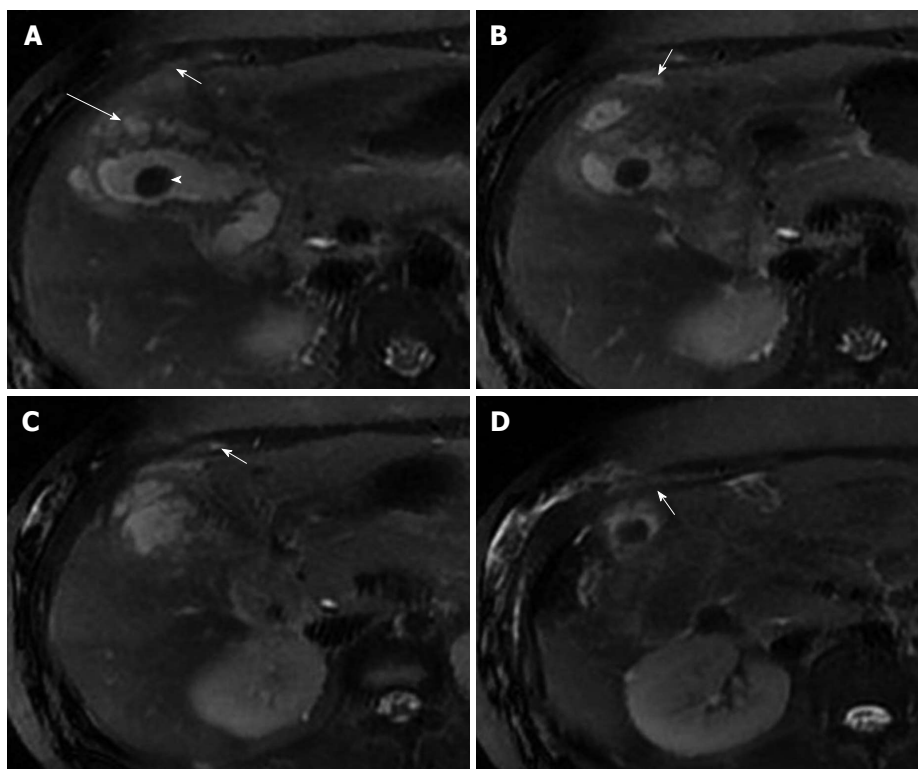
Axial sequential T2W magnetic resonance images (A-D) showing multiple hyper-intense intramural collections in gallbladder (long arrow) with extension of inflammatory process into the pericholecystic region, poor fat planes and involvement of the anterior abdominal wall (multiple short arrows). Note presence of intraluminal calculus (white arrowhead).
